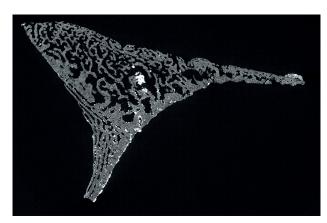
b μ-CT slice (resolution: 9.7 μm) showing a vermiculated reorganization of the medullary space; locally the sinuses are oriented perpendicular to the external table, with opening at the external surface as numerous porosities. This pattern reflects *hyperostosis spongiosa cranii* (© H. Coqueugniot)
